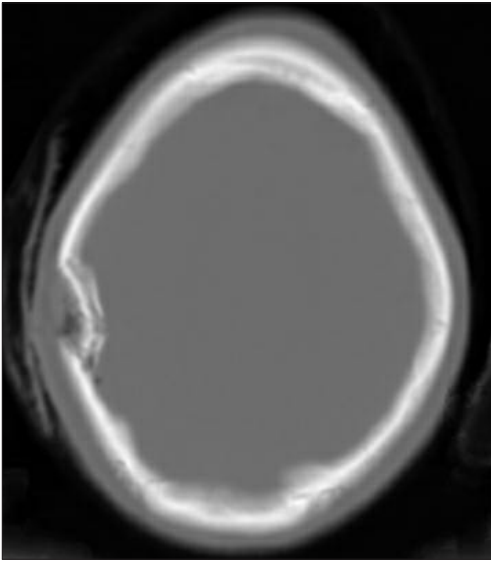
Computed tomography scan (bone window) showing a depressed skull fracture.
